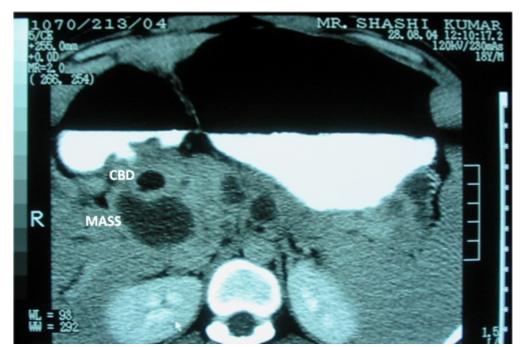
CT scan showing CBD dilatation due to neoplasm of the pancreas
